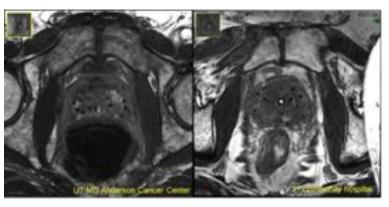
Fully balanced SSFP MRIs acquired without an ERC at (left) MDACC & (right) 1st community hospital using this LDRPBT MRI technique.
